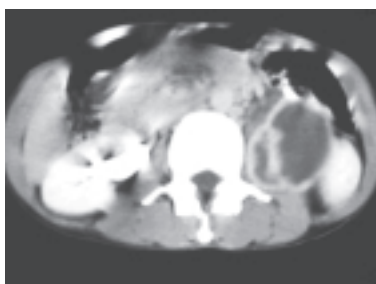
Enhanced axial CT scan taken at the level of the mid-pole of the right kidney.
